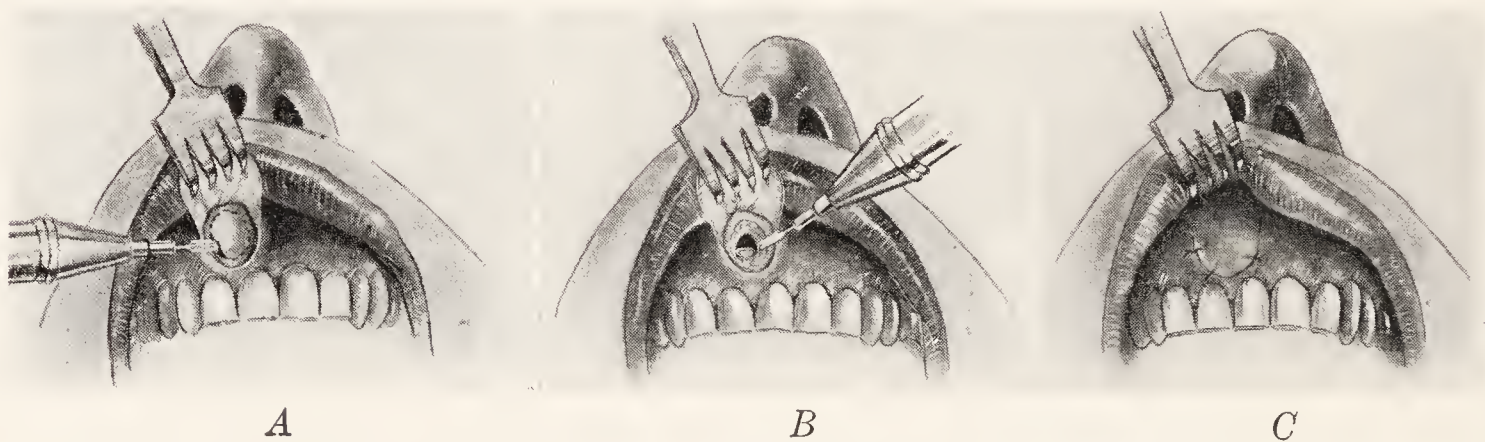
Technic of root resection. A, Shows gum flap turned up and the outer layer of the bone exposed. The window in the bone outlined with a Fisher burr. B, The window has been completely removed with the burr and the apex of the root has been removed. The periapical area is curetted. C, The flap is thrown down and a few sutures are placed to hold it. It is often well to stitch a roll of gauze over the flap for the purpose of pressure to prevent formation of dead spaces.
